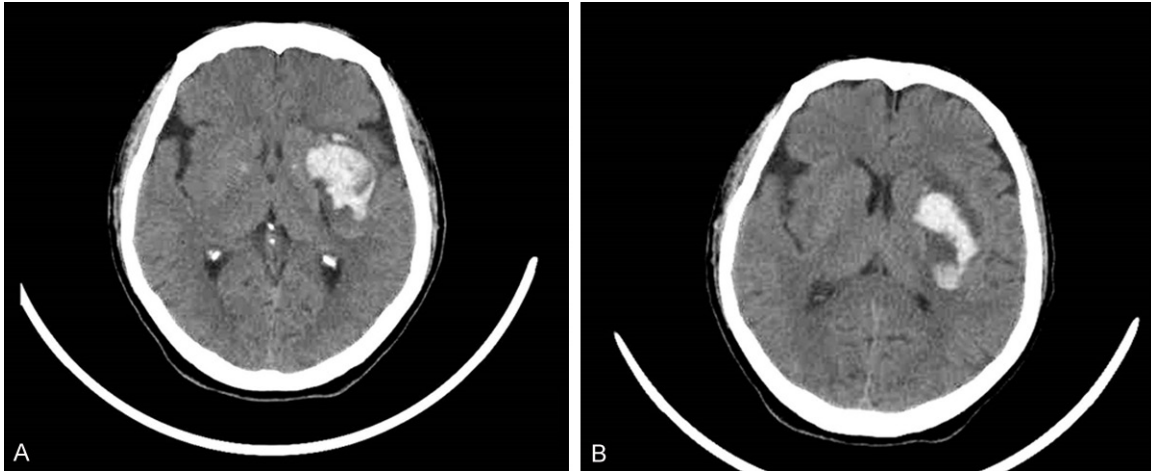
Case 3: A. Brain CT after 6 h for left basal ganglia intracerebral hematoma; B. Patients after 7 days drug treatment appeared the right side of mydriasis, recheck brain CT showed intracranial no fresh bleeding.
